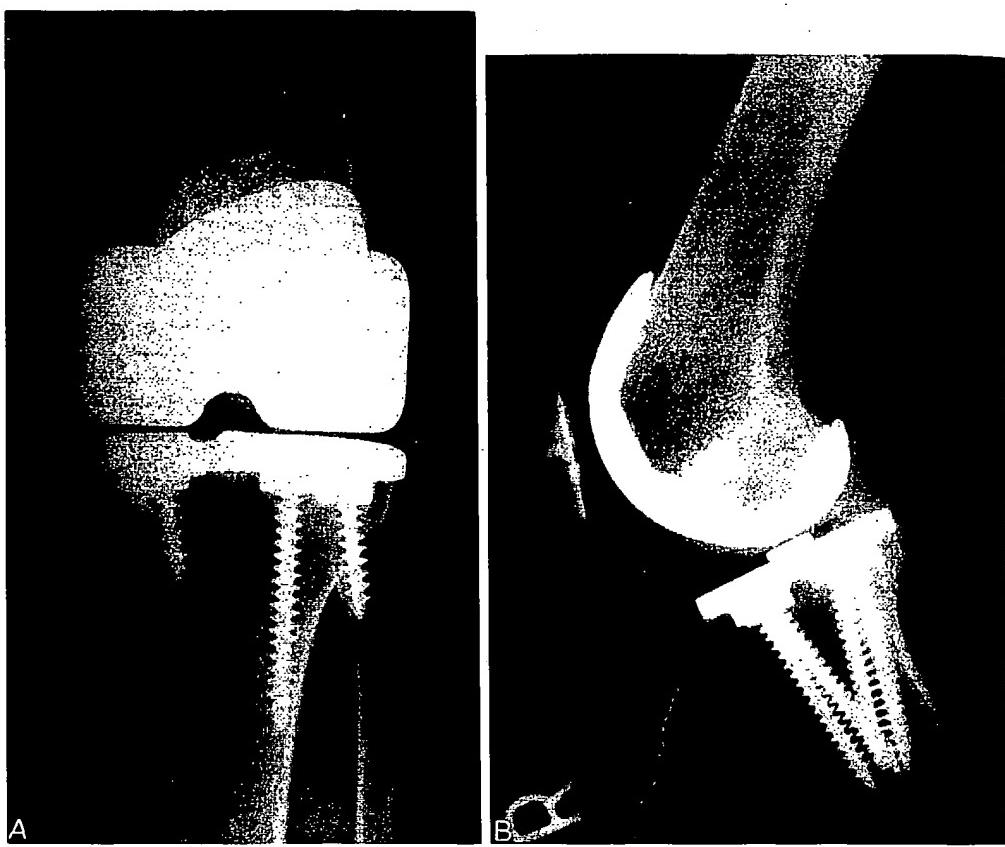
Anteroposterior and lateral radiograph of a loosened cementless TKA.
